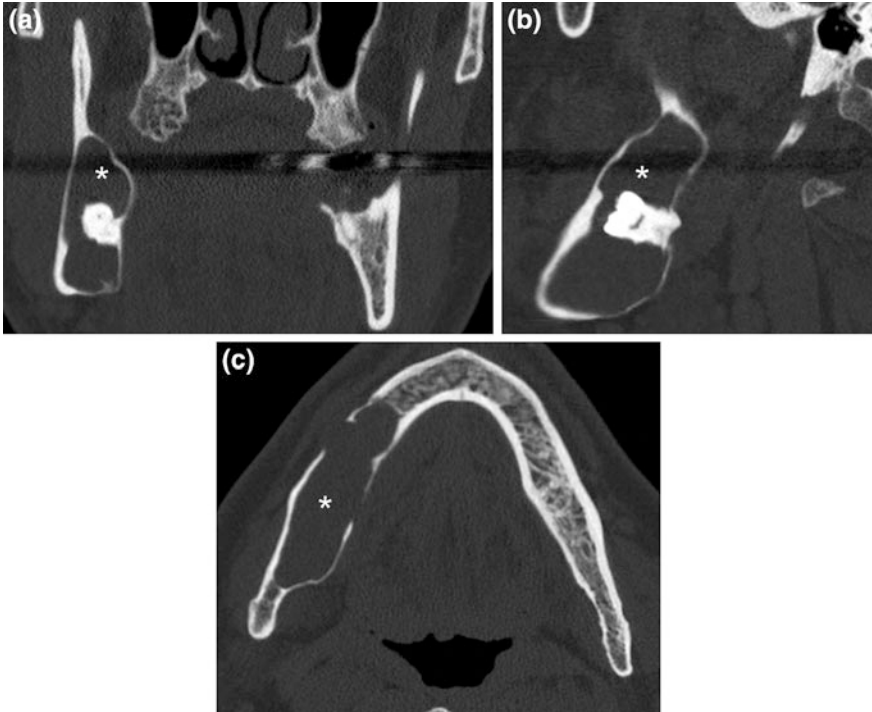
CBCT axial (a), sagittal (b) and coronal (c) sections showing an expansive osteolytic lesion located on the right mandibular body: well-circumscribed multi-loculated radiolucency bounded by a thin rim of cortical bone with smooth or scalloped margins (*). This lesion tends to expand the marked buccal-lingual and vestibular cortical bone. Note the dysodontiasis of 48. The radiographic signs suggest an ameloblastoma
